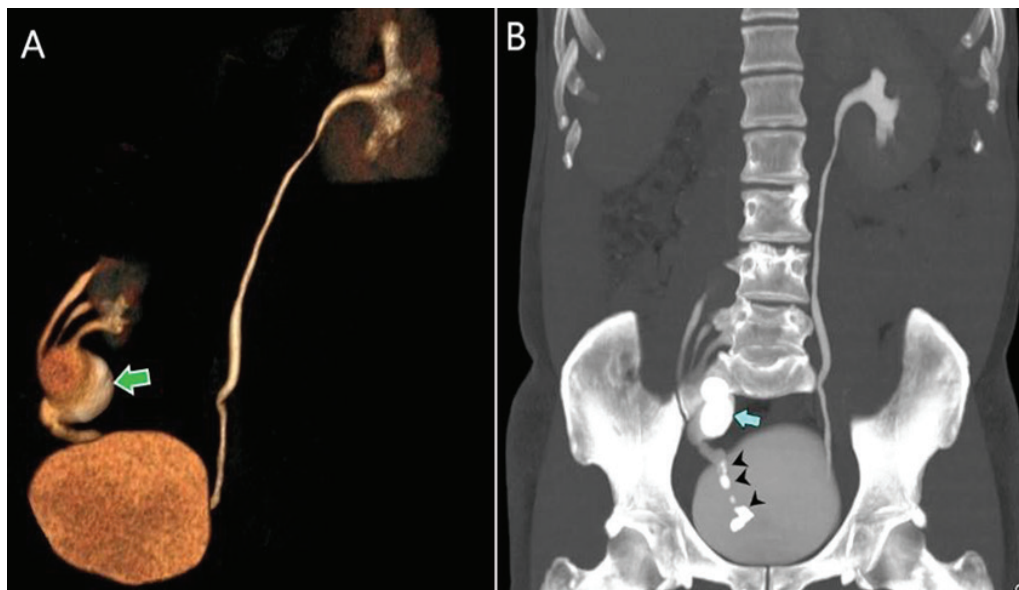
(A) A volume rendered reconstruction image of the computed tomography urography (CTU) showing three ureters arising from the right kidney and draining into a proximal ureteric cyst (green arrow). A distal monoureter is seen arising from the ureteric cyst. (B) A maximum intensity projection image of the CTU in the excretory phase showing two large calculi within the ureteral cyst (blue arrow) and multiple small calculi within the distal monoureter (arrowheads).
